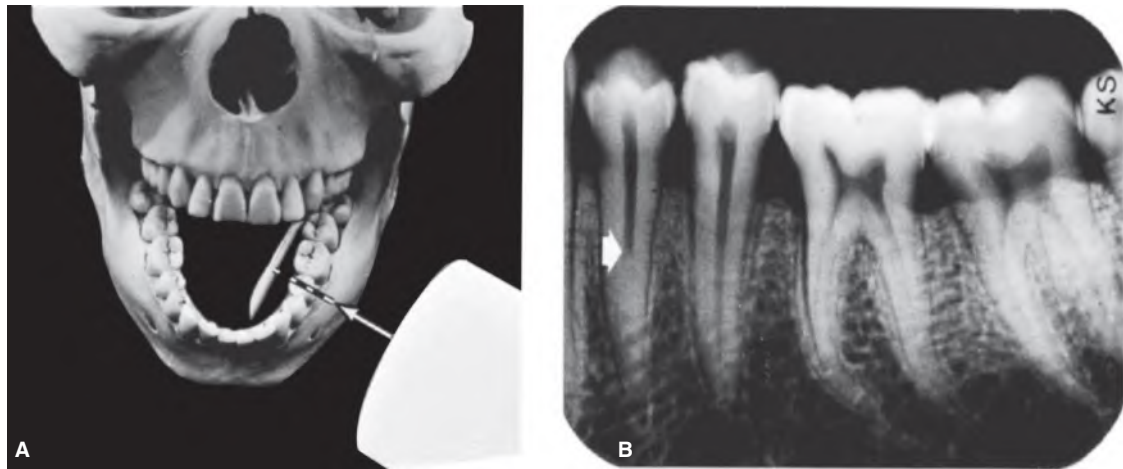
15 Mandibular premolars. A. Central ray directed at right angle to film positioned parallel to arch. B. Radiograph reveals one canal in each premolar, although abrupt change in density (arrow) may indicate bifurcation. (Reproduced with permission from Walton RE.²⁷)
